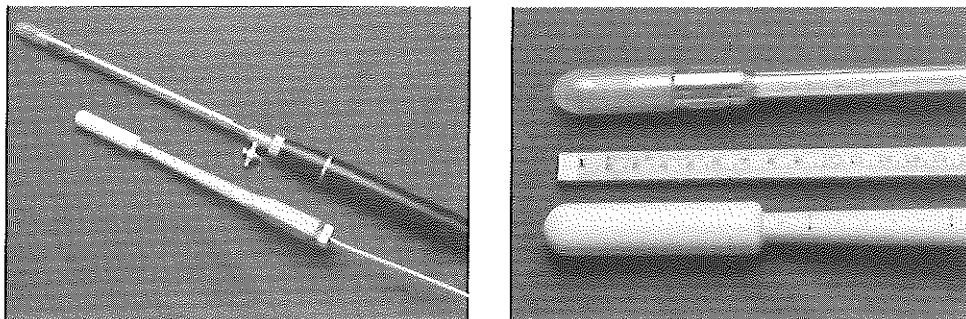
The endosonographic probe and the endoanal coil have a comparable diameter.
